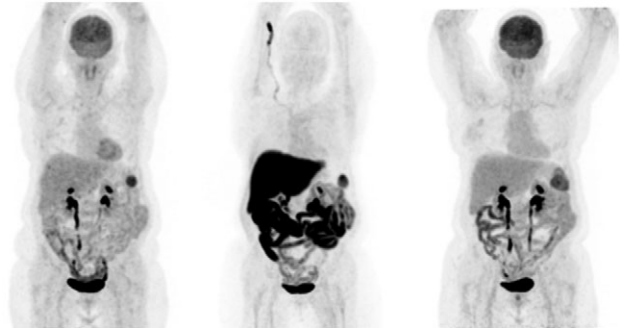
3D maximum intensity projection (MIP) anterior view from left to right: [^{18}F]-FDG PET on 6 February 2014, [^{18}F]-FES PET on 14 February 2014 and [^{18}F]-FDG PET on 25 April 2016 showing increased tracers uptake in the spleen metastasis
